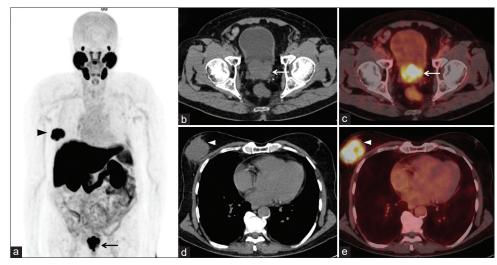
Maximum intensity projected image (a), axial computed tomography (b), and axial fused images (c) show increased tracer uptake in both lobes of prostate (arrows) consistent with disease recurrence. Increased prostate-specific membrane antigen uptake was also noted in the soft tissue mass in right breast parenchyma (arrowhead) in maximum intensity projected (a), axial computed tomography (d), and axial fused images (e)
